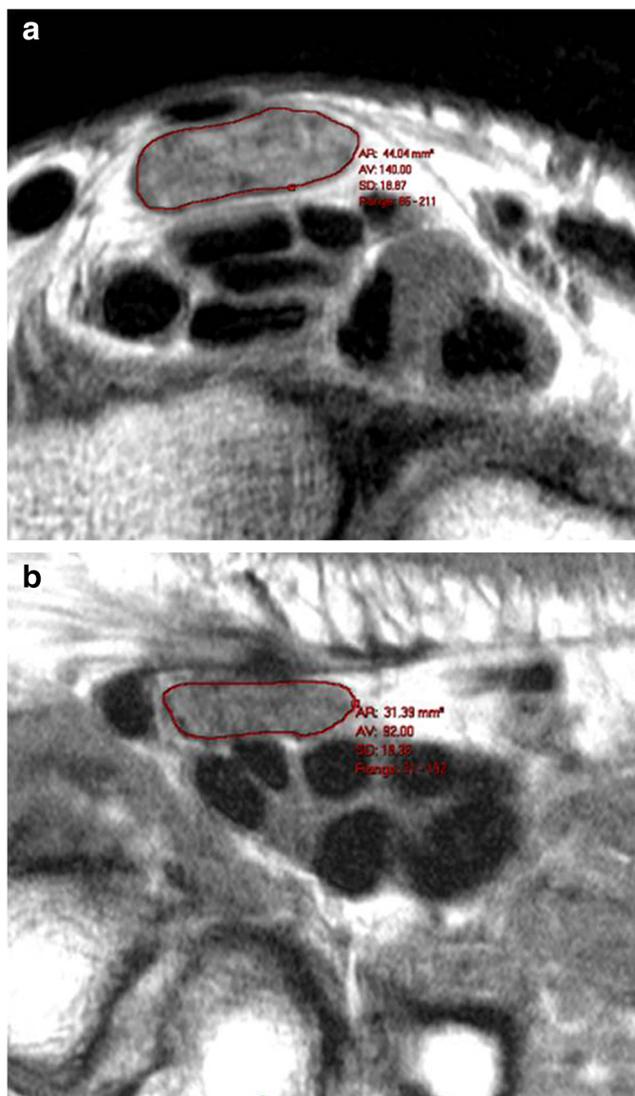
a Proton density axial MR image of a 51-year-old woman with CTS proximal to the carpal tunnel. The median nerve CSA outlined by the *solid line* is increased (44.04 mm²). b Proton density axial MR image of the same patient distal to the carpal tunnel. The median nerve CSA outlined by the *solid line* is also increased (31.39 mm²) but to a lesser degree than proximal to the carpal tunnel
